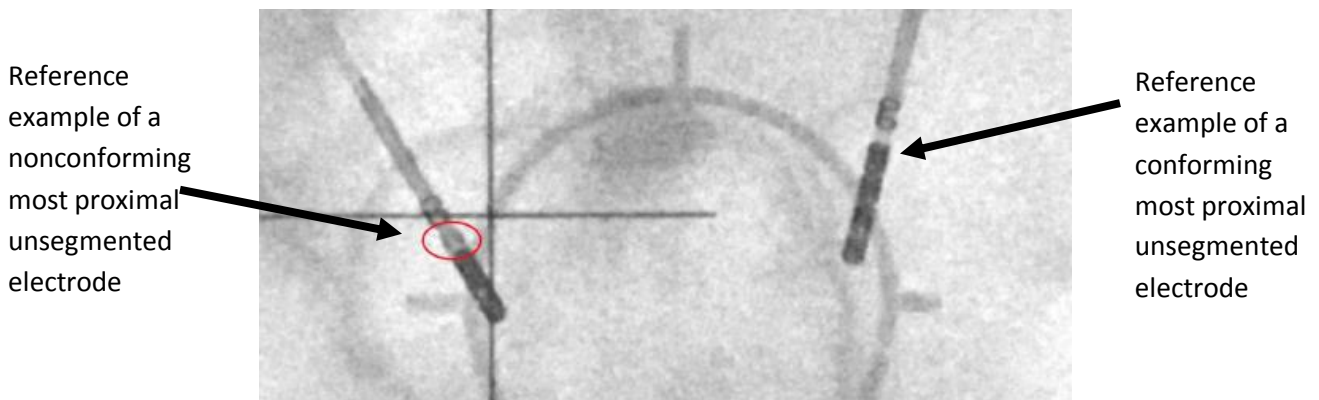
shows an example of a fluoroscopic lateral X-ray with a nonconforming and a conforming lead.
